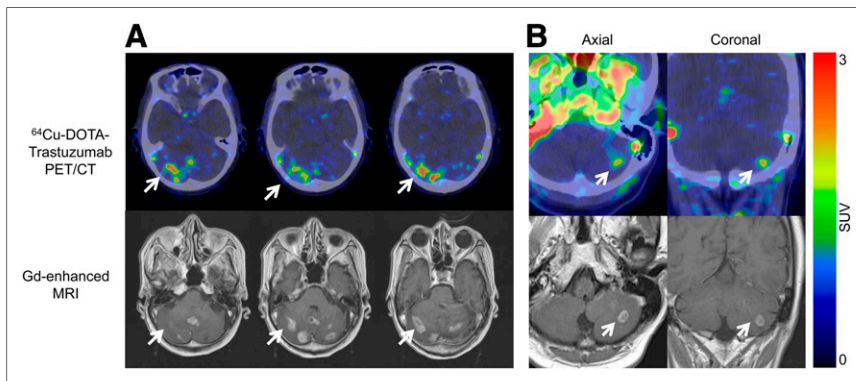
^{64}Cu -DOTA-trastuzumab PET images of HER2-positive metastatic brain lesions (arrows). (A) Brain metastases were clearly visualized by ^{64}Cu -DOTA-trastuzumab PET in patient 1. Significant uptake values were found in areas corresponding to brain metastatic lesions that were detected by MR imaging. Some brain metastases could not be detected on conventional CT. (B) In patient 4, ^{64}Cu -DOTA-trastuzumab PET imaging could detect solitary brain metastasis that had also been identified in similar location by MR imaging.
